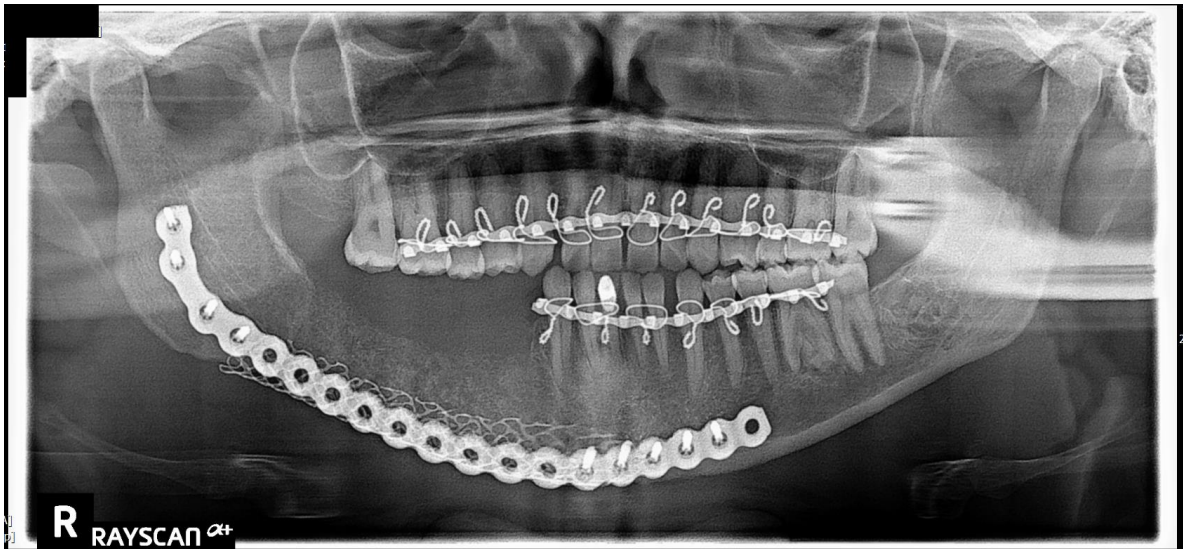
Post-operative (six weeks) panoramic radiograph.
